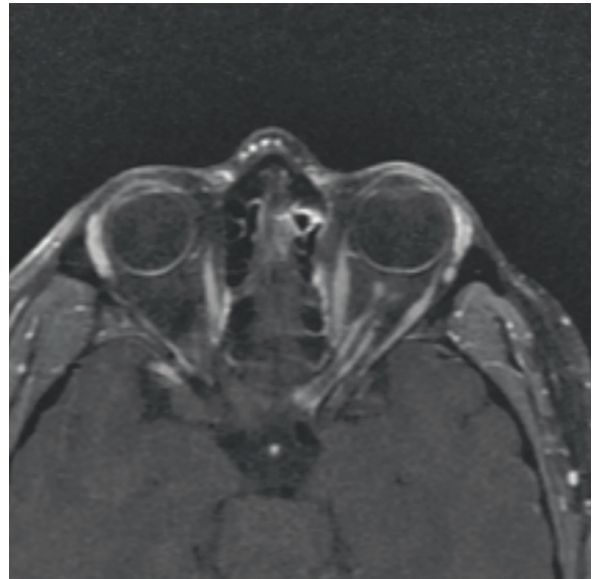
T1-weighted post-gadolinium axial MRI showing left optic nerve sheath enhancement with a “tram track” appearance.
